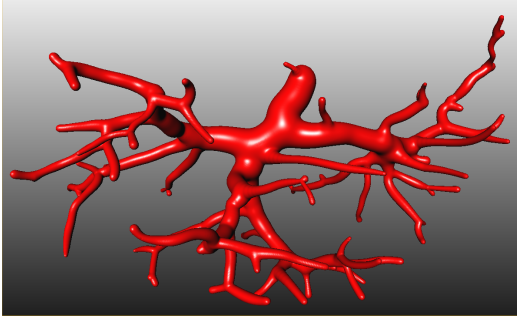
Visualization of the portal vein derived from a clinical CT data set with 136 edges.
